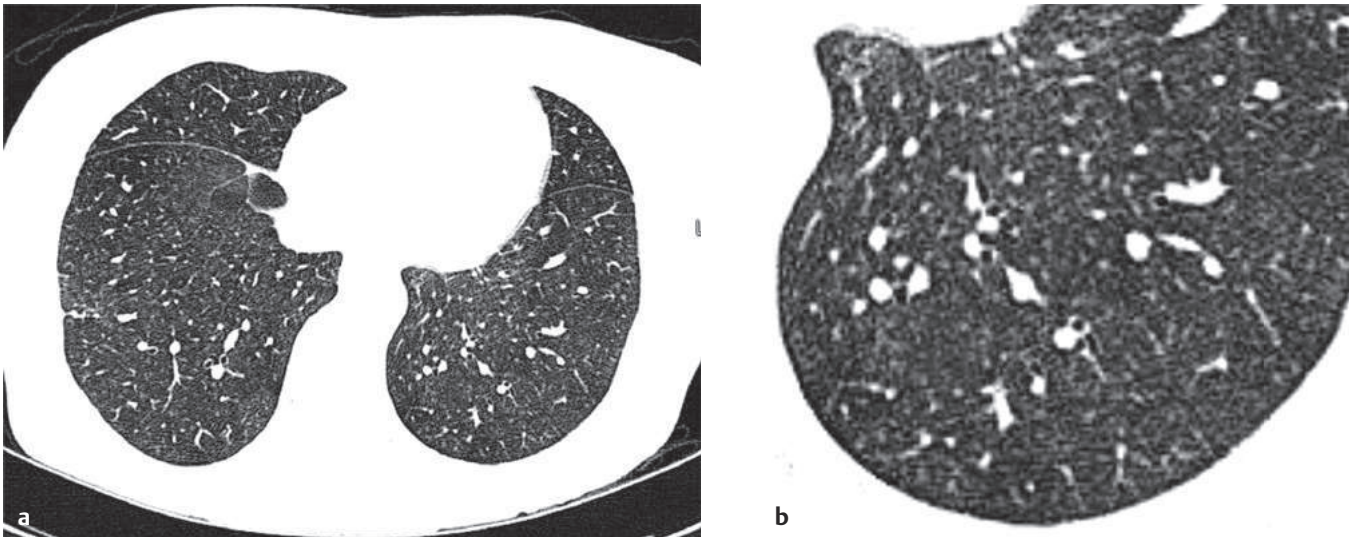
(a) Axial CT image through the chest and (b) coned-down view of the left lower lobe in lung window reveals diffuse bilateral ill-defined centrilobular ground-glass nodules.
